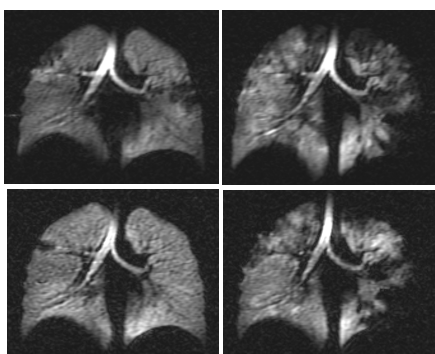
^3He MRI images at baseline (left column) and after Mch challenge (right column), at day 1 (top row) and day 2, 45 days later (bottom row).
